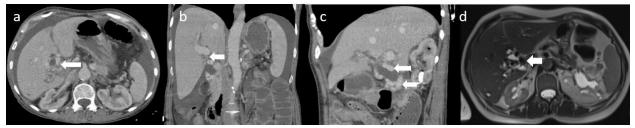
Axial contrast-enhanced Computed Tomography (CT) image (a) shows collateral venous shunts compressing the main bile duct (arrow). Coronal reformatted CT image (b) reveals severe luminal narrowing of the portal vein due to thrombosis (arrow), and sagittal reformatted CT image (c) shows pericholedochal vascular dilations compressing the common bile duct (arrow). Axial T2-weighted image (d) displays hypointense signal voids in collateral vessels compressing the main bile duct (arrow).
